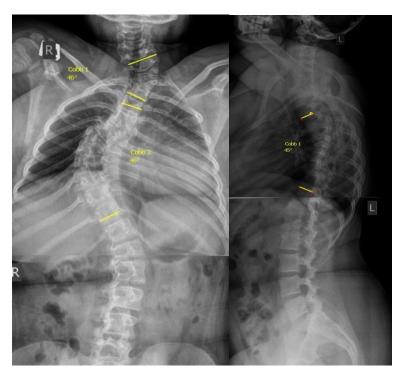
Radiographs of 11-year old patient spine with congenital S-shaped kyphoscoliosis with lateral hemivertebrae in the cervical and thoracic spine; leading defect is a disorder in vertebral formation, S-shaped combined kyphoscoliotic curve C6-Th2 with the apex at the level of C7 hemivertebra (relative): scoliotic component -46° Cobb, local kyphosis at the level of Th3-6-10 -43° . Thoracic scoliotic curve Th3-Th11 with the apex at the level of Th5 hemivertebra (relatively) -46°
